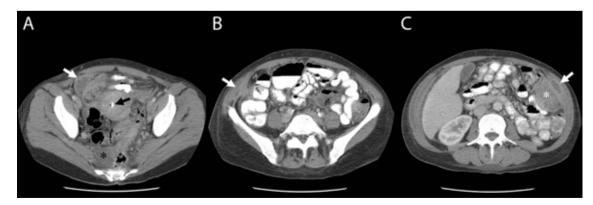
Axial computed tomograms with oral and intravenous contrast medium from the abdomen and pelvis of the same patient. (A) A low density collection with rim enhancement, consistent with an abscess, is seen in the right iliac fossa (white arrow); free fluid is seen in the presacral region of the pelvis (black asterisk); an intrauterine device is also present within the endometrial cavity of the uterus (black arrow). (B) Inflammatory thickening of the anterior abdominal wall musculature and underlying intraperitoneal fat is seen in the right iliac fossa (white arrow); compare this with normal appearances on the left. (C) A small rim enhancing collection is seen within the anterior abdominal wall musculature of the left upper quadrant consistent with another abscess (white arrow) and a bulky region of phlegmonous change in the underlying intraperitoneal fat (white asterisk). Although these features are non-specific, the constellation of inflammation and abscess formation across tissue planes in the presence of an intrauterine device is strongly suggestive of actinomycosis infection
